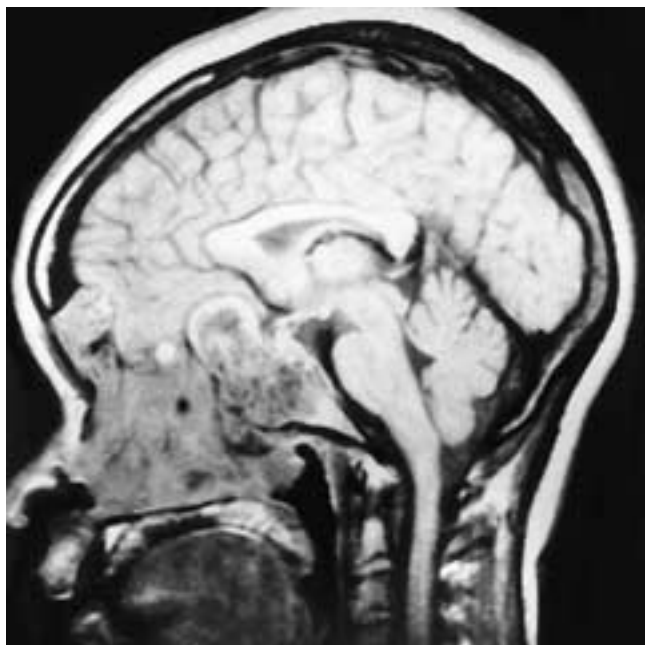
Sagittal T1-weighted MR image shows a nonhomogeneous signal intensity polypoid mass in the sphenoid and ethmoid sinuses, breaking intracranially. Increased soft tissues are also present in the nasal fossae. This patient has polyposis.
